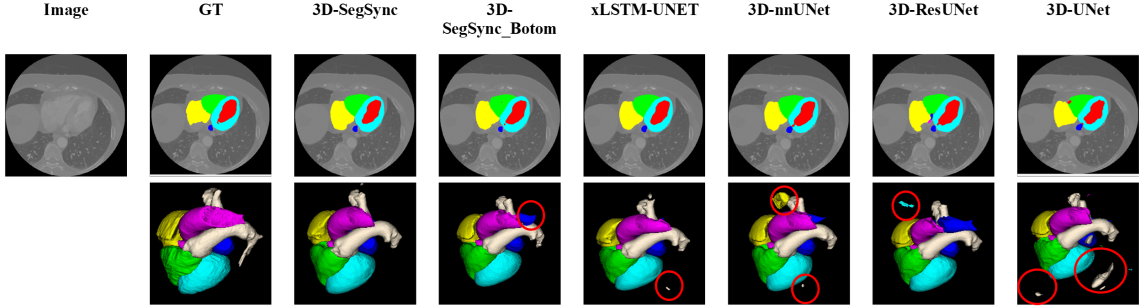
Quantitative Performance of the Proposed and SOTA Models on the MMWHS CT Dataset. Colour representation: Purple (AO), Yellow (RA), Red (LV), Light Blue (Myo), Gray (PA), Blue (LA), Green (RV).
